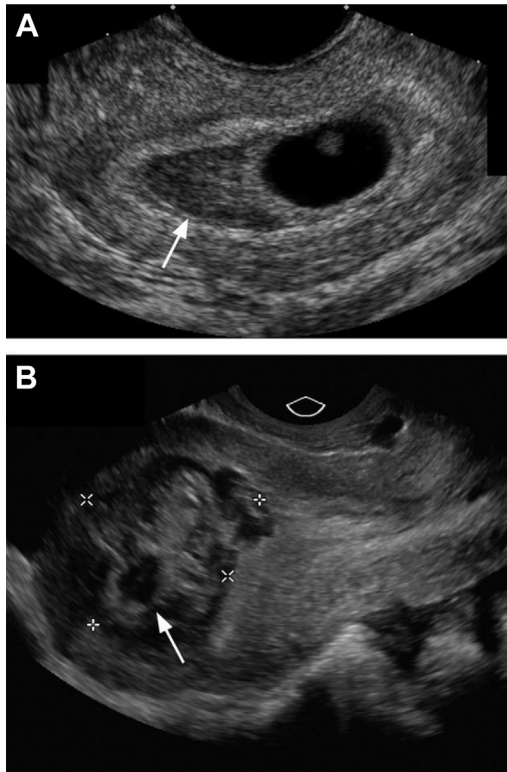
Subchorionic hematoma⁶² (A) Small, hypoechoic subchorionic bleed (less than one third of circumference of GS; arrow). (B) Large subchorionic bleed with heterogeneous echogenicity (between calipers) surrounding the GS (arrow). (From Mazzariol FS, Roberts J, Oh SK et al. Pearls and pitfalls in first-trimester obstetric sonography. Clin Imaging 2015;39:176-185.)
